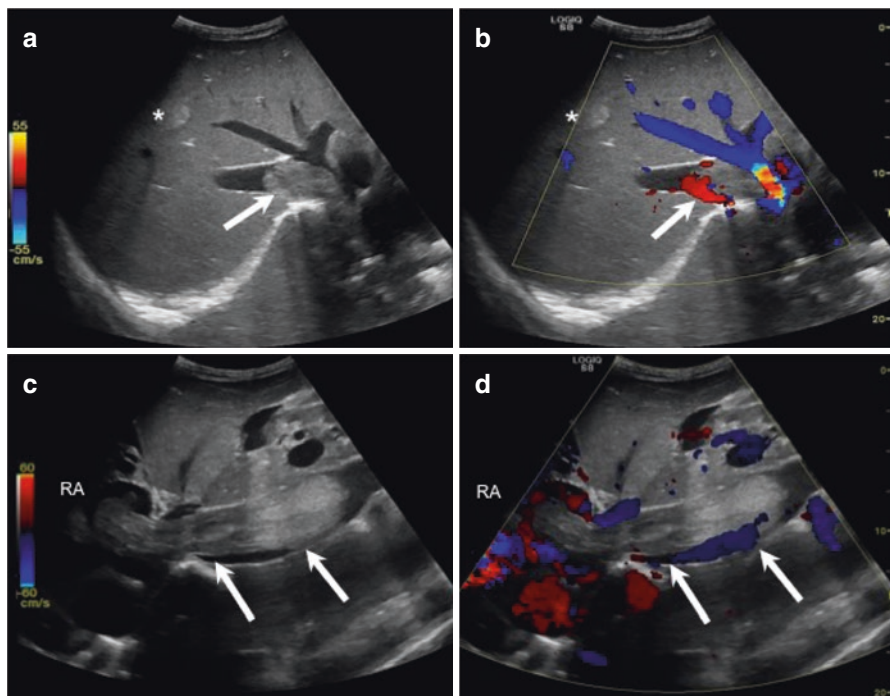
Hepatic metastasis (*) associated with hematic thrombosis of the intrahepatic inferior vena cava (arrows) with cranial extension to the right atrium. B-mode US (a, c) and color Doppler US (b, d) images
